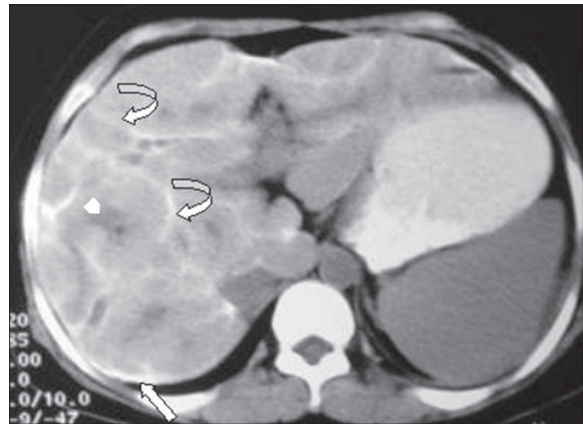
Case 1. Un-enhanced CT of abdomen: capsular (straight arrow) and septal calcifications (curved arrows) giving a pathognomonic appearance. Other features are irregular hepatic contour, periportal fat and fibrosis (arrow head).
